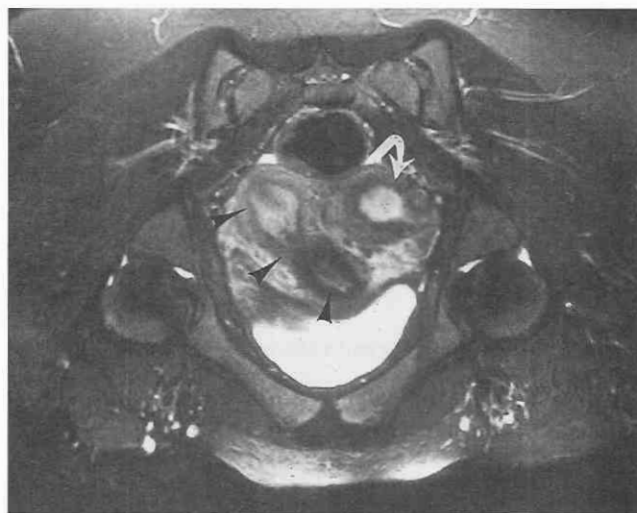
Unicornuate uterus with a noncommunicating rudimentary horn. An off-axis (oblique) T2-weighted fat-saturated image (TR 3500/TE 90/180 degrees) shows a hypoplastic left uterine horn (curved arrow) that does not communicate with the normal right uterine horn (arrowheads). Both uterine horns are deviated laterally.
